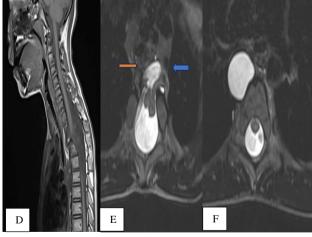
(A-F): T1W and T2WI Cervicothoracic spine MRI in sagittal plane-midline vertebral body defects noted in D1, D2 and D3 vertebral bodies with herniating thecal sac anteriorly and posteriorly. Short segment syrinx is noted at C7-D1 and D4-D6 vertebral levels (green arrows). T2W MR in axial plane. Thecal sac containing CSF is seen in right paravertebral region with the neural elements (Orange arrow). The hypointense neural placode is seen attached to left anterolateral wall of sac (Blue arrow).
